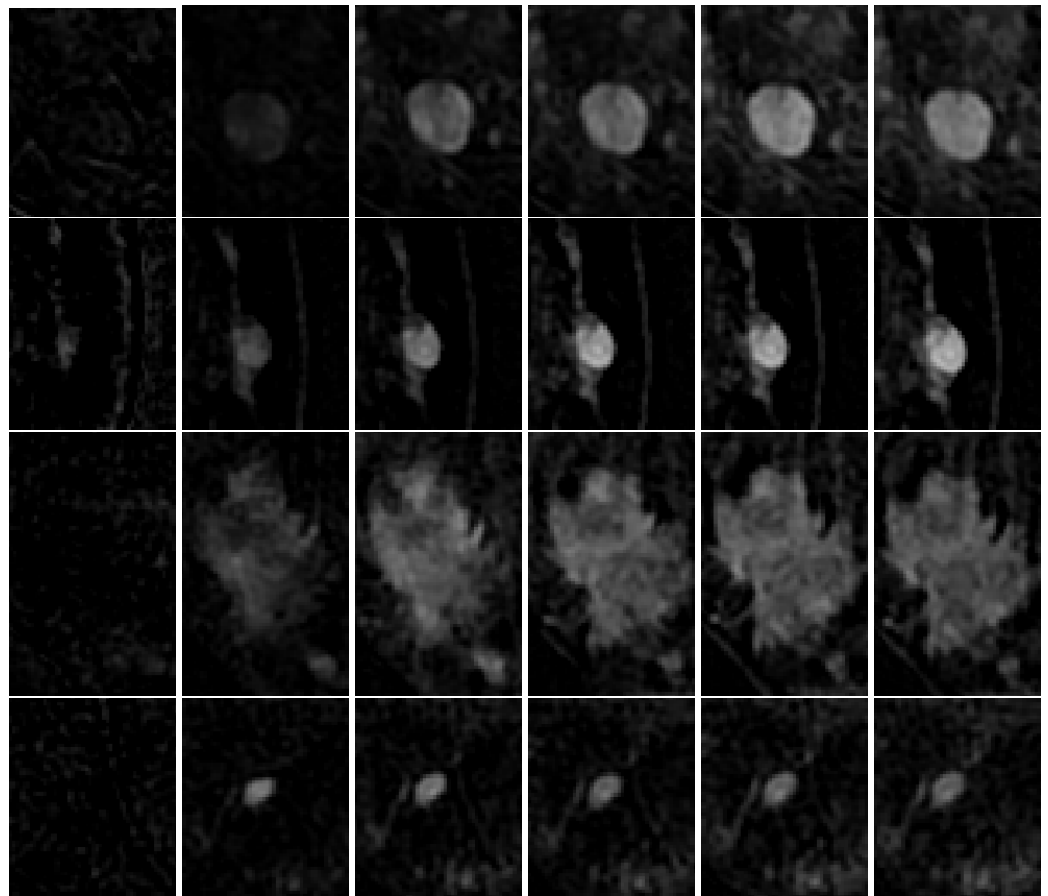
Examples of DCE-MRI phases related to four breast cancer patients (one per row): malignant lesions are shown on rows 1 and 3, while benign lesions are shown on rows 2 and 4. Among phases, for segmentation purposes the clinician selected the strongest one. In particular, for these lesions, the 4th, 3rd, 4th, and 3rd phase was chosen, respectively.
